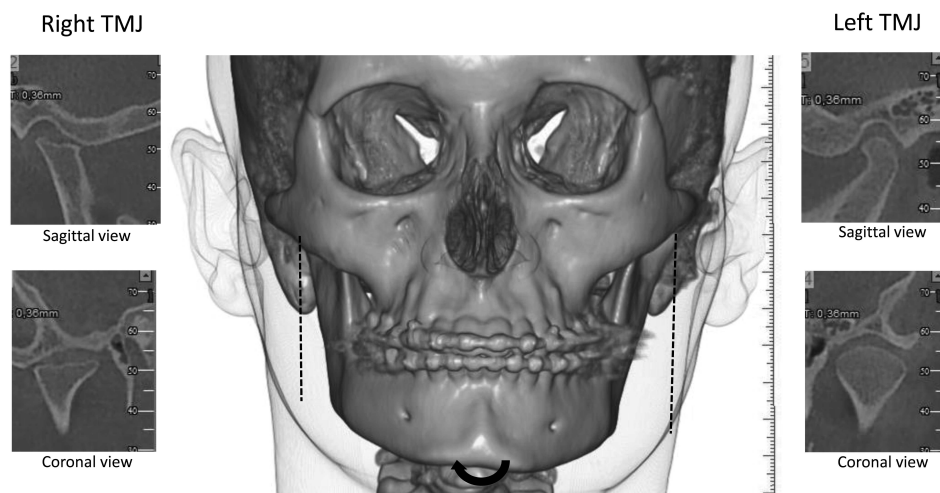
Fifteen-year-old girl with isolated arthritis in the right TMJ causing functional disabilities and moderate orofacial symptoms. Right TMJ: radiological signs of pronounced TMJ deformity with condylar flattening and erosive surfaces changes. Left TMJ: normal condylar outline and shape of TMJ components. Full-face cone-beam computerized tomography displays pronounced arthritis-induced dentofacial asymmetry; reduced vertical mandibular development on the right side compared to left side (dotted lines). The interside difference in vertical development leads to an abnormal mandibular growth-dependent rotation, indicated by the black arrow. TMJ: temporomandibular joint.
